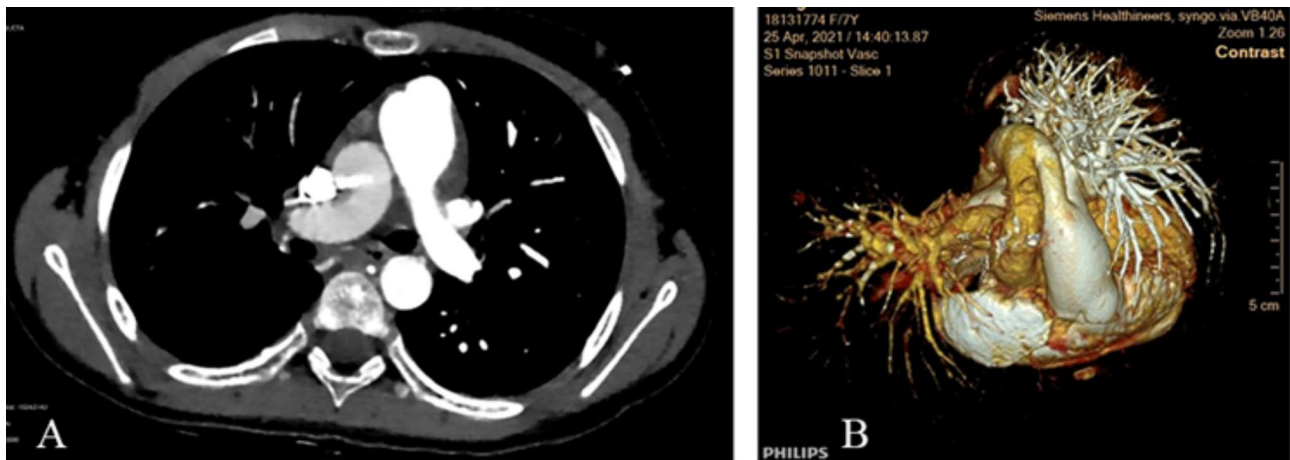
CT pulmonary artery angiography. (A) The right pulmonary artery arises from the ascending aorta; (B) the arterial duct lies between the left pulmonary artery and the descending aorta. PA, pulmonary artery; RPA, right pulmonary artery; LPA: left pulmonary artery; PDA, patent ductus arteriosus; AAO, ascending aorta; DAO, descending aorta
